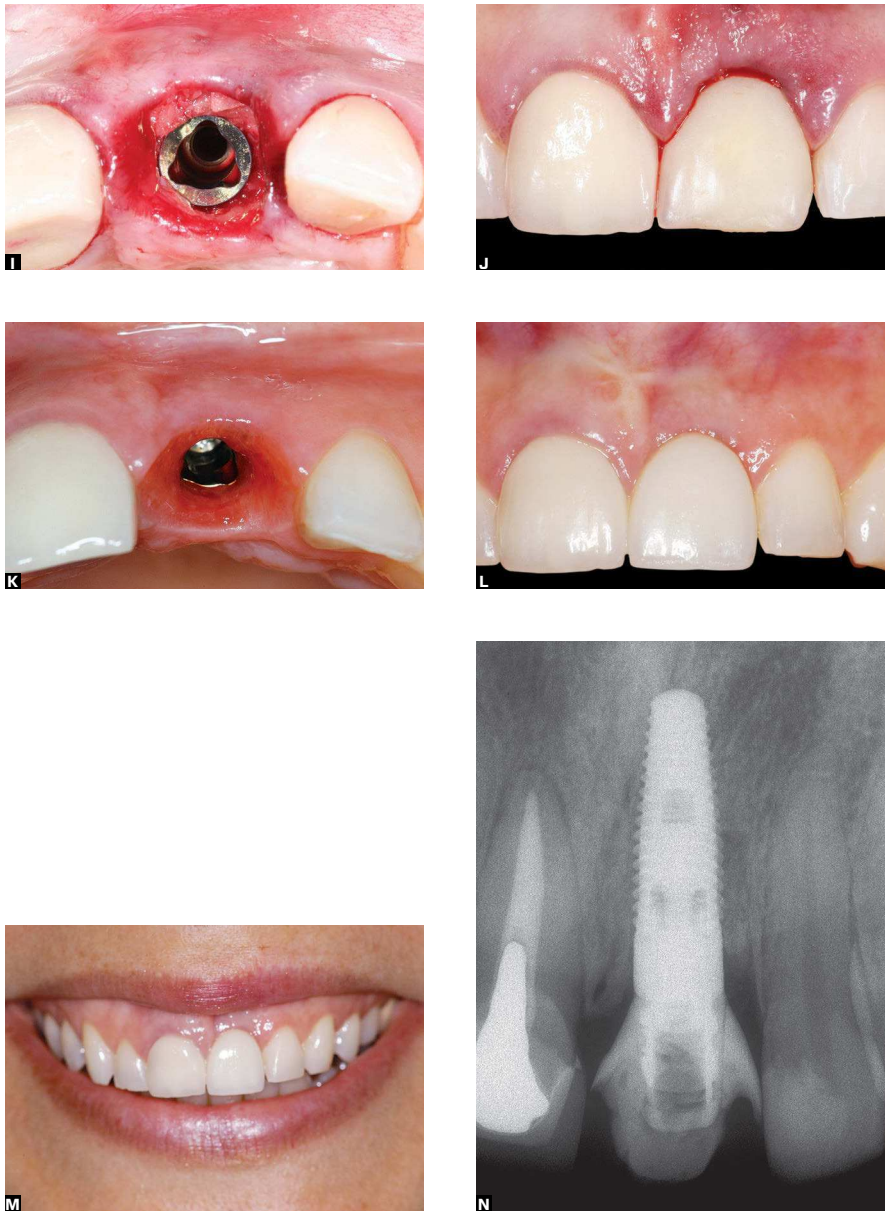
I) Occlusal view shows autogenous graft in place between implant and buccal gingiva tissue. J) Provisional restoration screwed over implant. K, L) Clinical aspect 6 months after implant placement: tissues around crown have a favorable progression. M) Final smile with satisfactory transition between crown and gingiva. N) Radiograph after placement of prosthetic crown over implant (2 years follow-up).
